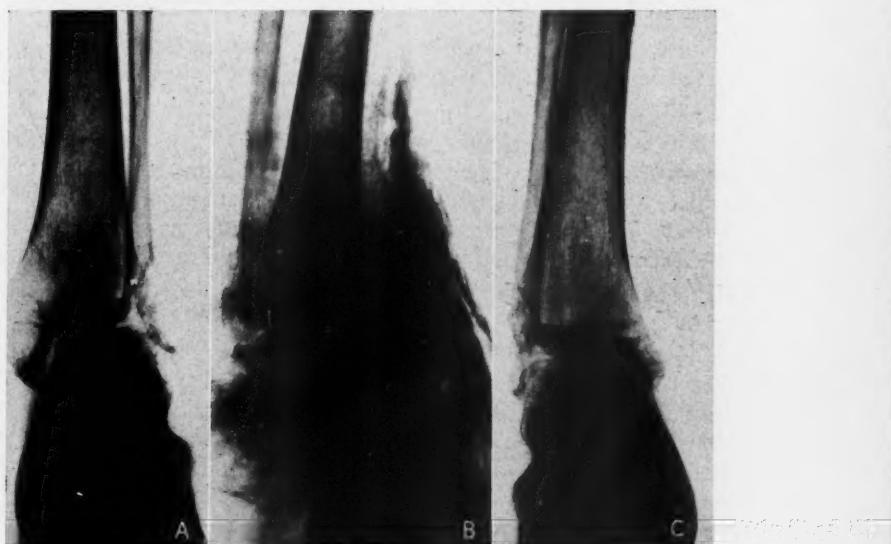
W. P. Male, 25. *A*. Old malunited fracture of the left ankle with foot displaced laterally. *B*. X-ray after fracture was reduced. Crossed Kirschner wires drilled through internal malleolus into the shaft of the tibia, thus locking the fragments securely. Wires removed at the end of 4 weeks. Cast removed at 6 weeks. *C*. X-ray two months after the operation showing perfect position of the astragalus beneath the tibia. Malleoli solidly united in their normal position. No residual disability.
